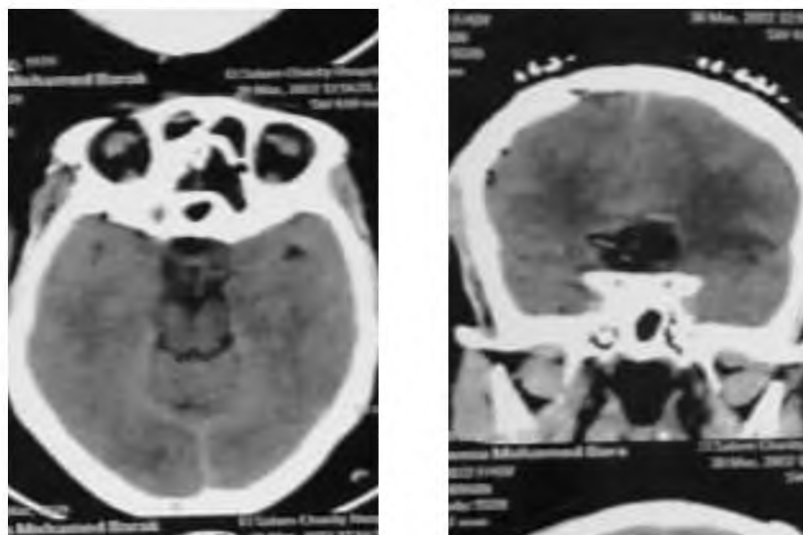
Post operative CT brain of planum sphenoidal meningioma.
